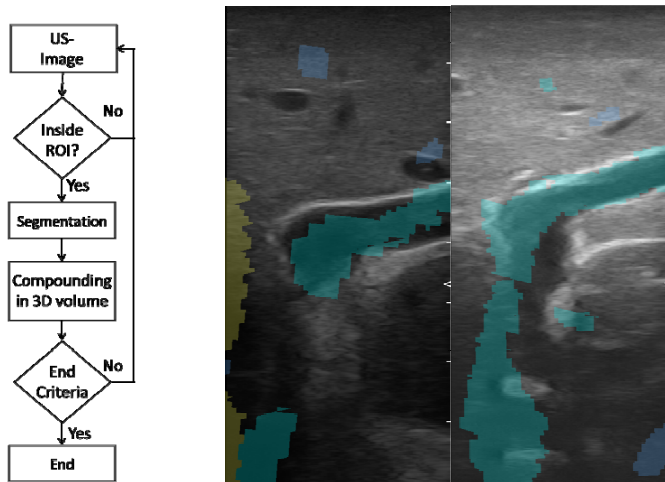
a) Feedback loop algorithm for 3D US acquisition. b) Intra-operative assessment of navigation accuracy. Anatomical information from MeVis-CT is overlaid to the US view.
